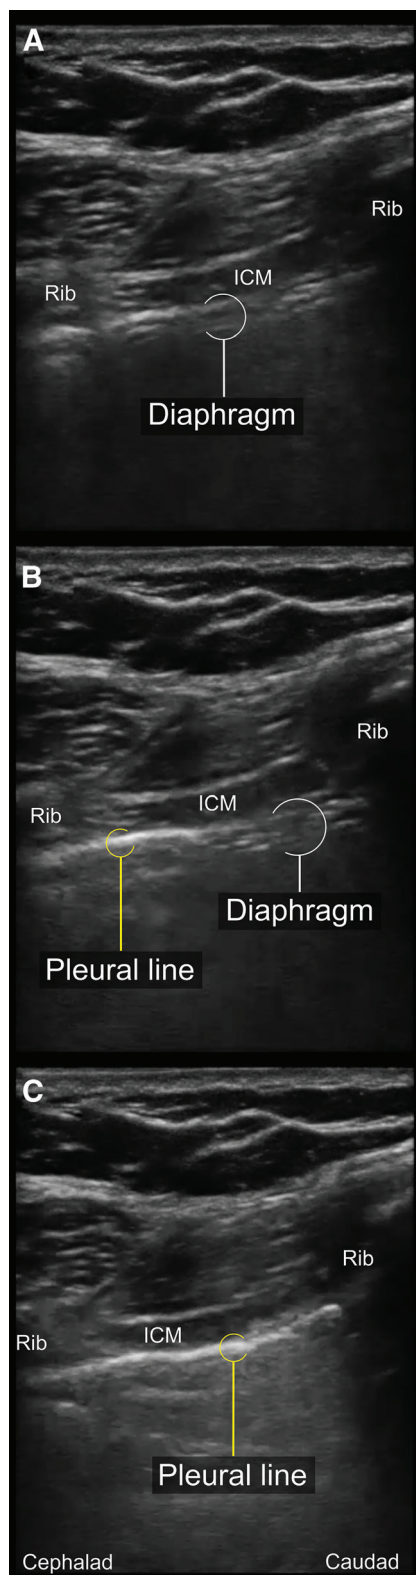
Linear array transducer ultrasound image of the pleura in the right midaxillary line at the level of the seventh and eighth ribs in (A) early inspiration; (B) mid-inspiration; and (C) end-inspiration. The pleural line (yellow circle) can be seen progressively descending with inspiration. The intercostal muscles (ICM) lie superficial to the diaphragm (white circle).
